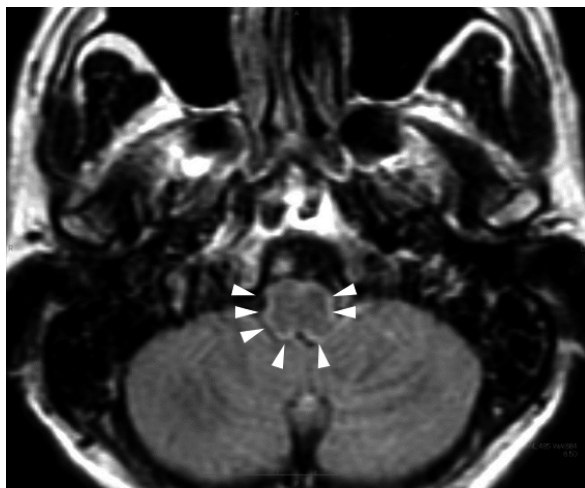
MRI findings at the level of the brain stem. A gadolinium-enhanced axial FLAIR image shows a diffuse leptomeningeal enhancement around the medulla oblongata (white arrow heads).
